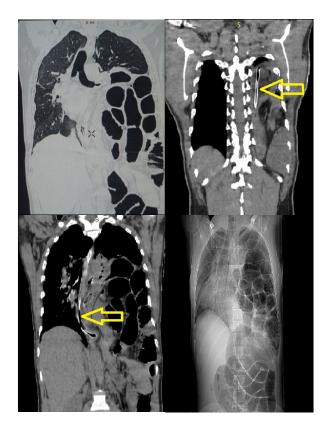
Longitudinal computed tomogram showing giant left sided diaphragmatic hernia with dilated bowel loops (yellow arrow pointing at Ryles tube into the stomach).
